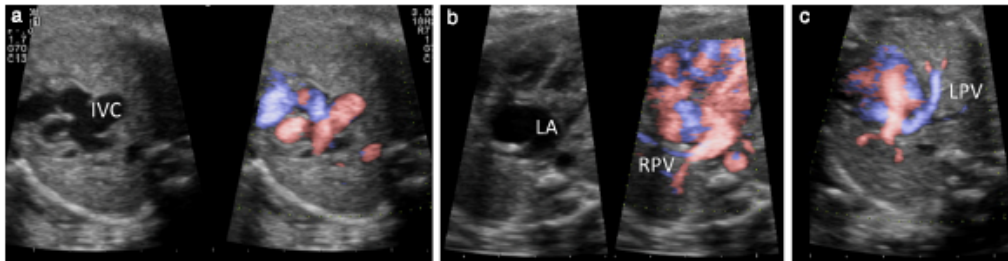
Fetal echocardiography with and without high-definition color imaging, at 26 weeks' gestation, showing: (a) significant dilatation of inferior vena cava (IVC) at its entrance to right atrium and (b,c) abnormal pulmonary venous connection to unroofed coronary sinus. LA, left atrium; LPV, left pulmonary vein; RPV, right pulmonary vein.
